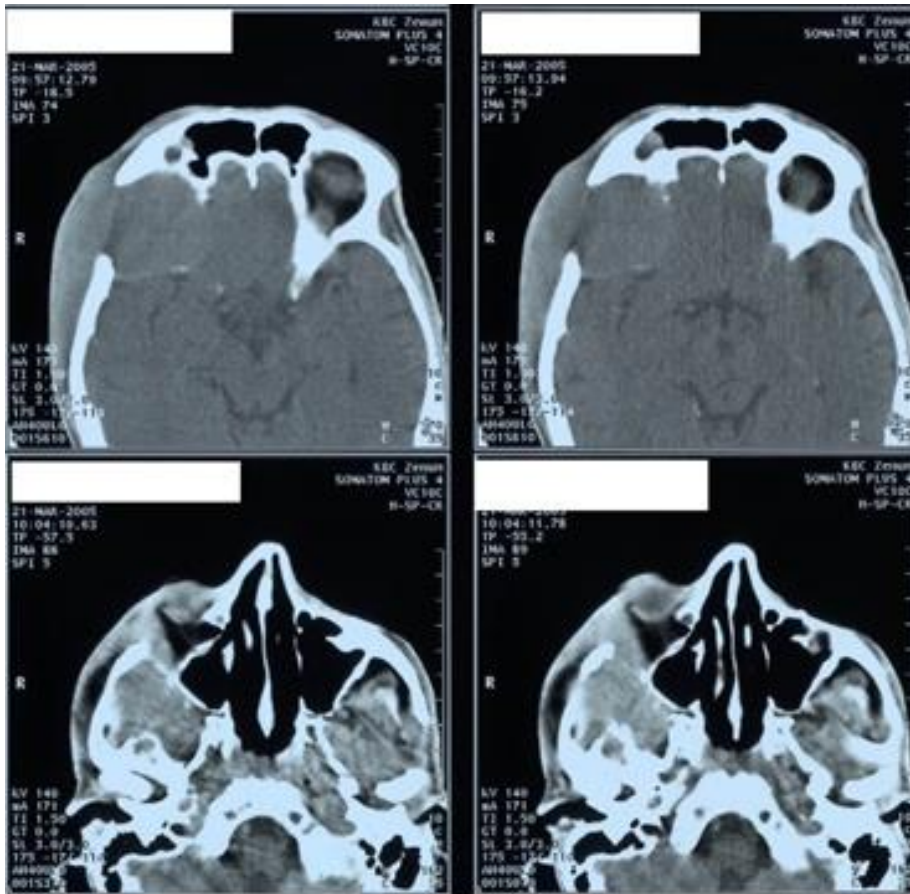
Computed tomography scan of the endocranium, showing tumor infiltrating the base of the skull, zygomatic bone, and the walls of the orbit, with the penetration in the endocranium
